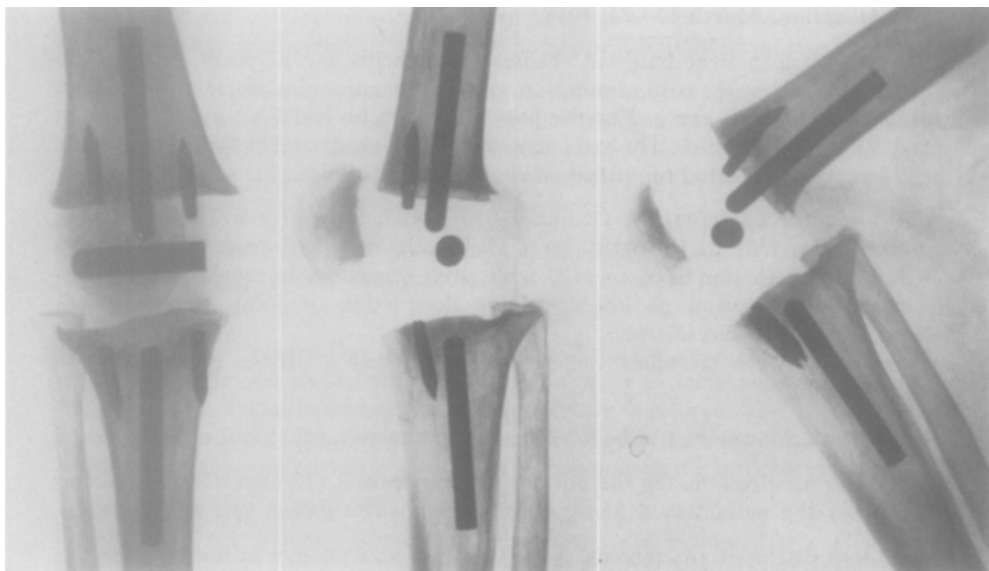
Case 8: roentgenograms of right knee 3 $\frac{3}{4}$ years after arthroplasty.
